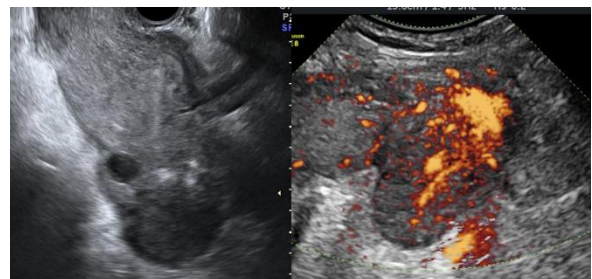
Sonographic gray-scale and power Doppler findings in patient with ovarian vein thrombosis. Gray-scale image of the left edematous ovary (*left*). Vascular engorgement (passive hyperemia) within left ovarian parenchyma visualized by power Doppler (*right*).
